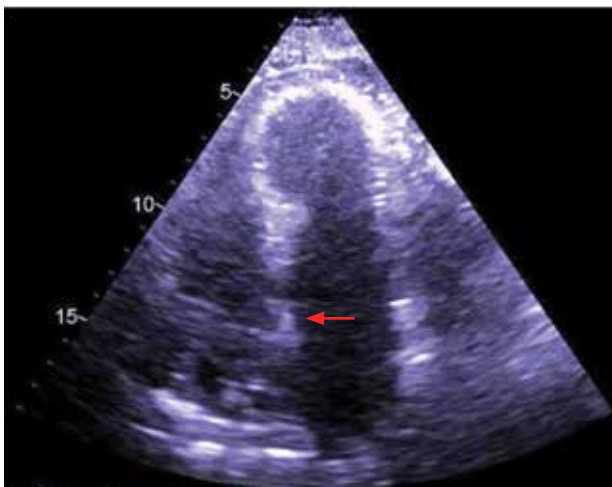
Two-dimensional echocardiogram apical 4-chamber view showing a mass in the right atrium.
